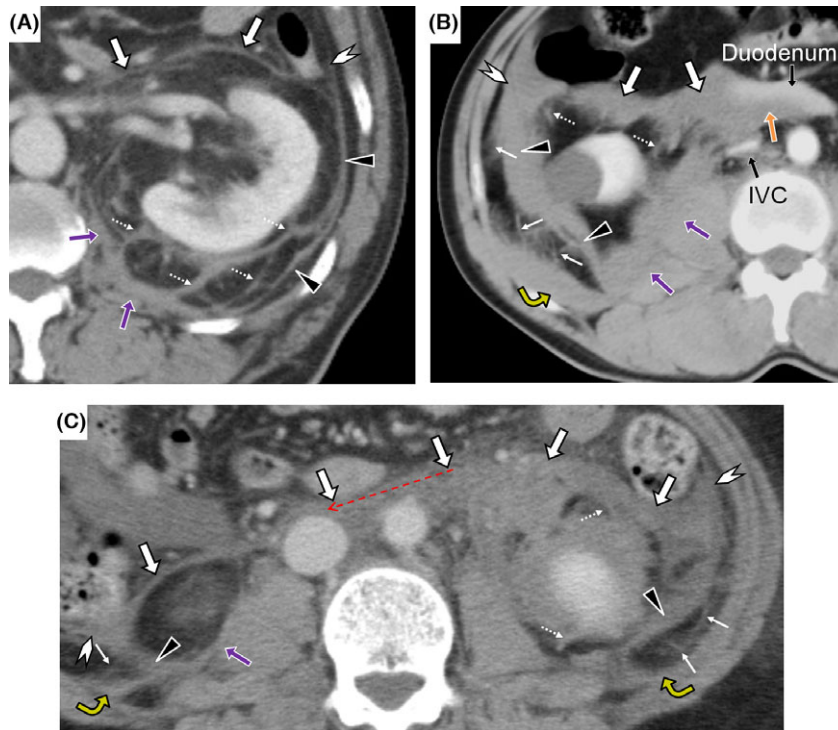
Traumatic retroperitoneal hematoma. A, A 74-year-old man with left renal injury. Computed tomography (CT) image on admission shows hematoma sequentially spreading from perinephric bridging septa (thin dotted white arrows) in the perirenal space (Type II) to the retromesenteric (white thick arrows), retrorenal (black triangles), and lateroconal (white arrowhead) planes. Note that the psoas muscle and quadratus lumborum muscle are located close to the hematoma within the medial part of the retrorenal plane (purple arrows) as well as in panels B and C. B, A 62-year-old man with lumbar spine injury. CT image on admission shows massive retroperitoneal hematoma spreading from the medial part of retrorenal plane (purple arrows) (Type IV), resulting from lumbar fracture and lumbar arteries, into the retromesenteric (white thick arrows), lateroconal (white arrowhead), and lateral part of the retrorenal (black triangles) planes and into the subfascial plane, showing the checkmark sign (gold curved arrow). He died from uncontrollable hemorrhage. Note that the hematoma in the retromesenteric plane is closely located to and elevates the duodenum (shown with orange arrow), and that many strands are detected within the posterior pararenal space (thin white arrows) as well as thickened perinephric bridging septa (thin dotted white arrows). C, A 44-year-old man with left renal injury. CT image 3 days after injury shows massive retroperitoneal hematoma travelling into the undamaged right retroperitoneum (red dotted arrow) through the retromesenteric plane (white thick arrows) from the perinephric bridging septa (thin dotted white arrows) in the perirenal space (Type II). Hematoma also extends to the retrorenal (black triangles and purple arrow) and lateroconal (white arrowheads) planes. Note bilateral checkmark signs (gold curved arrows) and strands (thin white arrows) in the posterior pararenal space.
